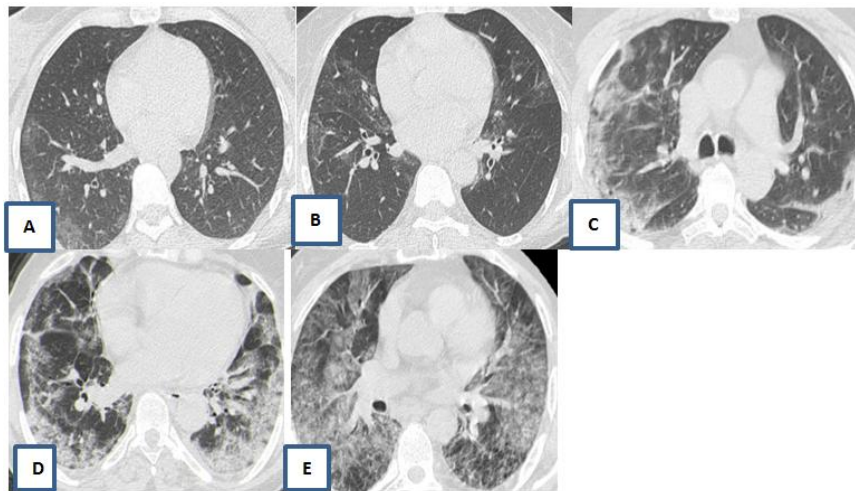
Chest CT with axial plane showing the extent of the invasion: minimal (A), moderate (B), extended (C) sever cases (D) and critical (E)
